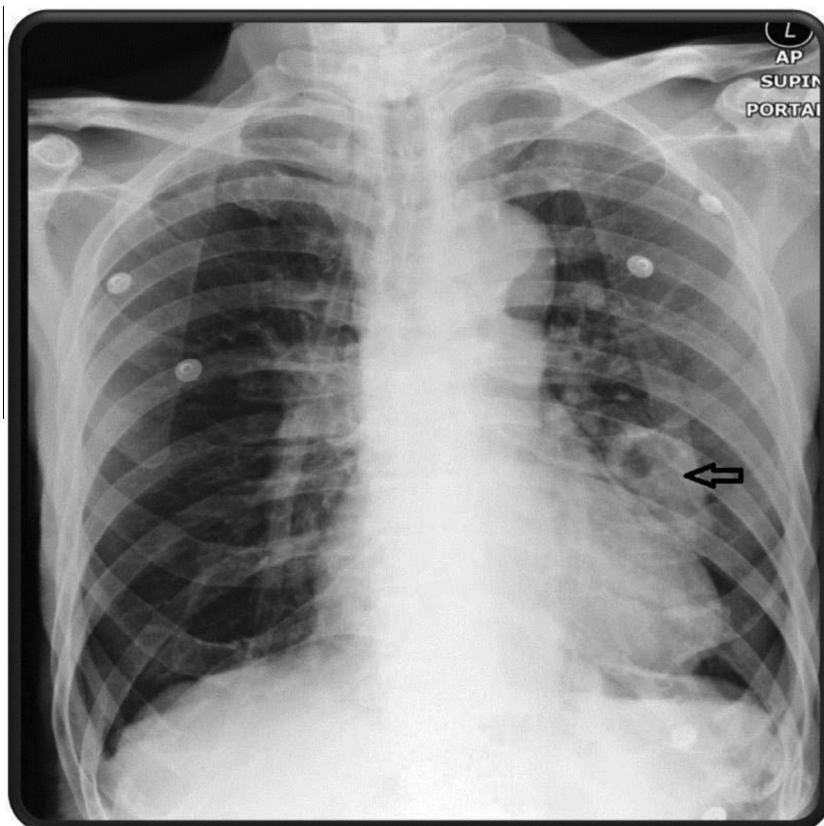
Chest X-ray showing multiple nodular cavitory lesions involving the left lung (arrow).
